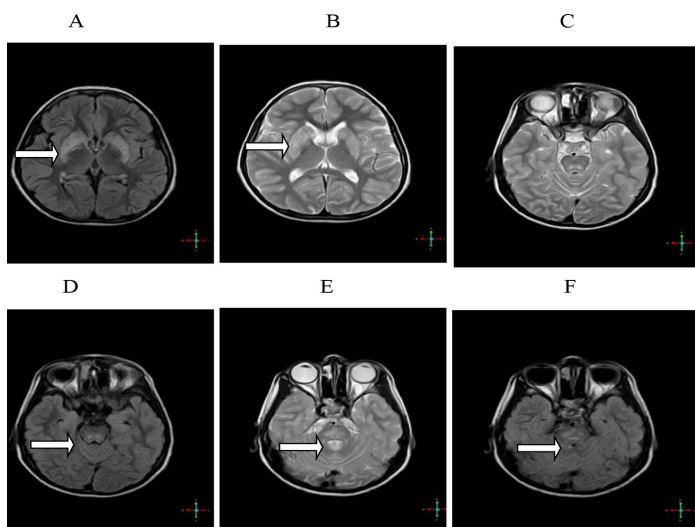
MR images of the brain. (A, B) FLAIR and T2W images shows bilateral caudate and lentiform nuclei hyperintensities. (C, D, E and F) shows bilateral hyperintensities in Pons.
